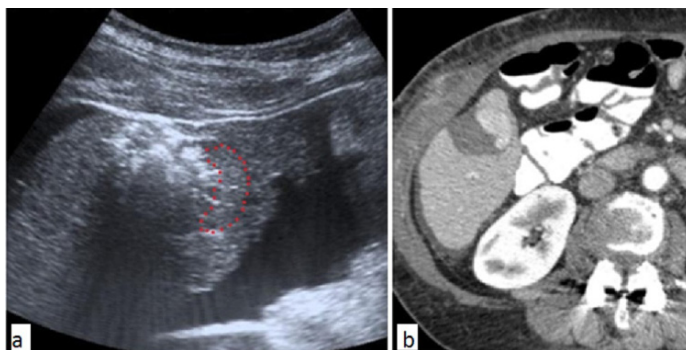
a. US image shows that the tips of an expandable electrode within the subcapsular lesion. There is no active electrode in the dotted field and gas bubbles which is the indicator of the ablation. b. Same patient as in (a) 1 month after ablation, abdomen contrast-enhanced CT, arterial phase, nodular rim enhancement indicates residual tumor present.
